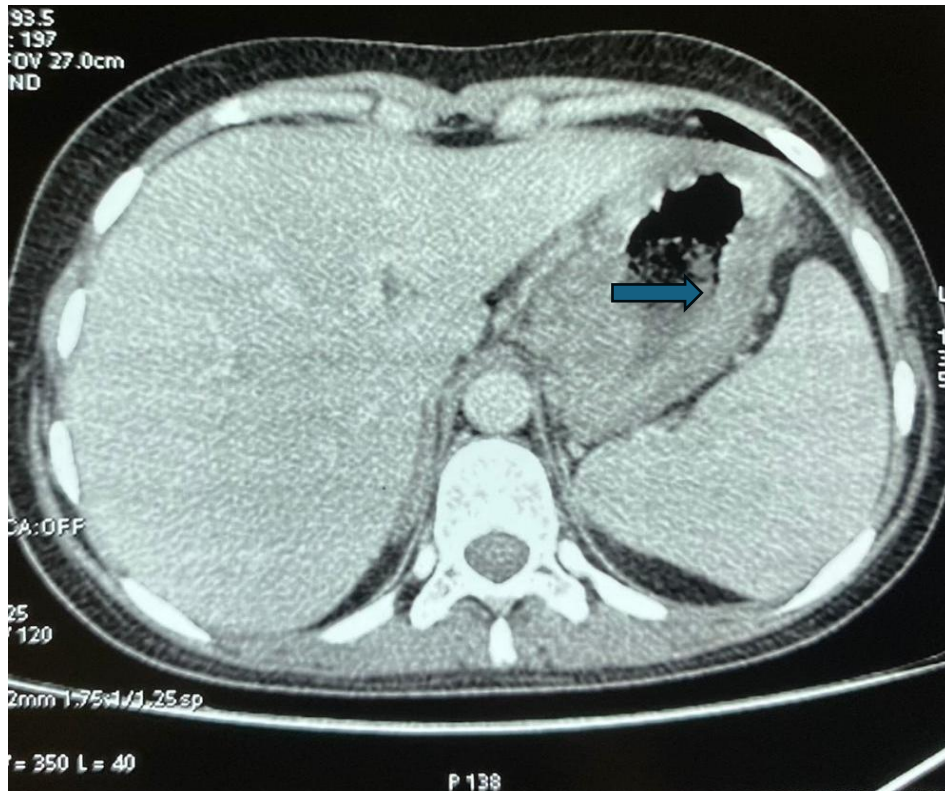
Abdominal CT with contrast shows gastric wall thickening with enhancement. (Arrow)
